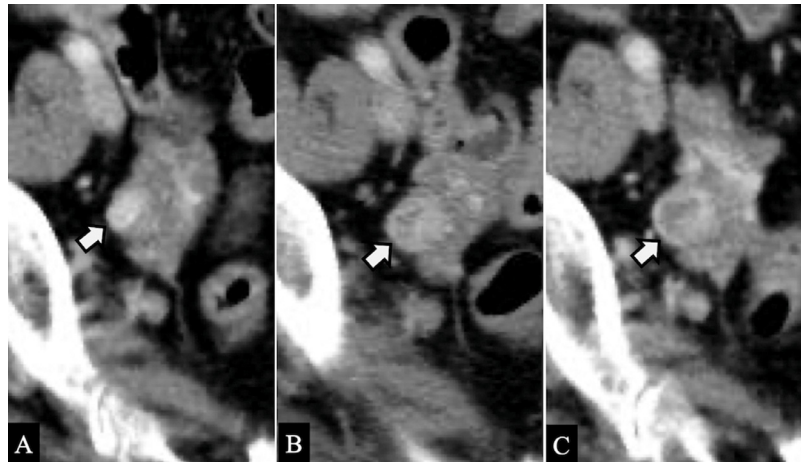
Change over time of the ovarian metastasis: (A) 1 year earlier from detection, (B) at the time of detection, and (C) 9 months after detection. Serial contrast-enhanced computed tomography is shown. (A) A homogeneous, well-enhanced 10 mm mass in the right ovary can be retrospectively recognized 1 year before detection. (B) The mass has increased slightly to 16 mm in size by the time of detection. (C) Tumor size has not changed significantly at 9 months; the necrotic part of the tumor has slightly enlarged.
